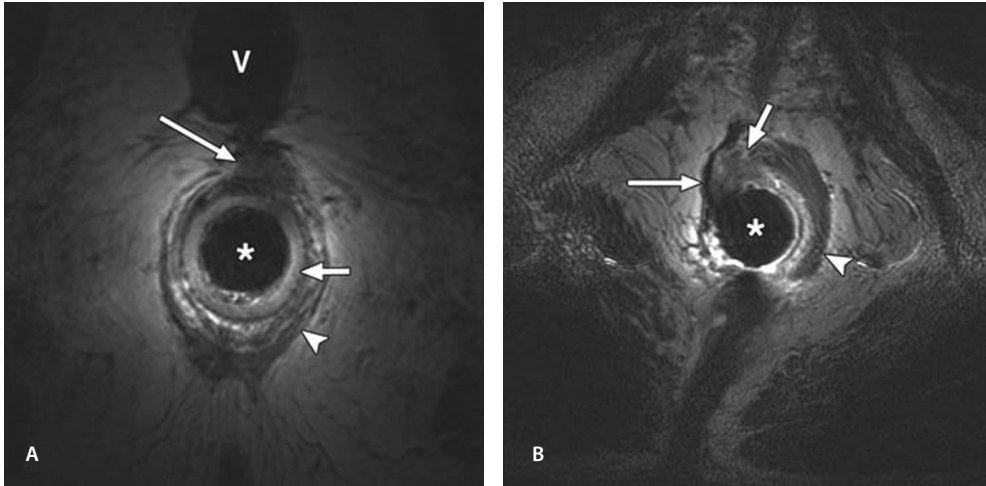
Examples of cases in which MRI findings suggested scarring of the anus. Asterisk indicates endoluminal coil in anal canal. A, 62-year-old woman 5 years after anterior anal repair for persistent anal and perianal pain that had lasted 1.5 years. Axial T2-weighted MR image shows scarring (long arrow) of anterior aspect of external anal sphincter (arrowhead) and perineum but clinical examination revealed levator ani syndrome as cause of pain. Short arrow indicates internal anal sphincter. V = vagina. B, 59-year-old man 7 years after surgery for perianal fistula disease. Chronic anal and perianal pain had lasted for 2 years with no abnormalities found at proctoscopy or examination under general anesthesia. MR image shows part of intact muscular structure of external anal sphincter (arrowhead) on left side. On right, external anal sphincter is replaced by hypointense linear structure (long arrow) suggestive of fibrotic strand with anterior adjacent area of intermediate signal intensity (short arrow). These abnormalities were interpreted as scarring at MRI, and obvious painful local stiffness was found at clinical evaluation. Final diagnosis was potentially painful scarring.
